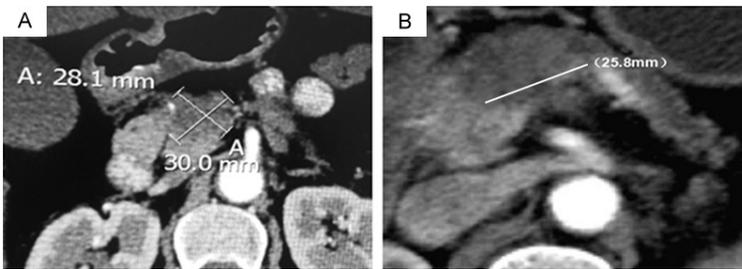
Cross-sectional CT scanning images of the pancreatic cancer primary tumor from a patient in (A) Air Force General Hospital, Beijing, China; and (B) General Hospital, Beijing, China.
